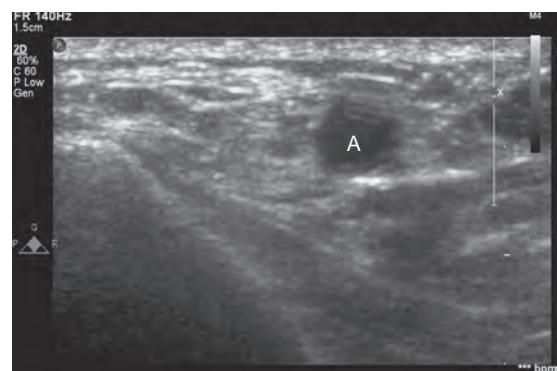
Typical ultrasound image during short-axis (transverse) cannulation.
